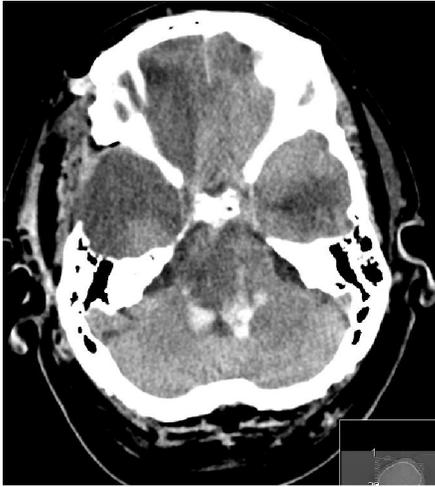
A non-enhance CT brain shows a lower cut than figure 5, at the pons level, demonstrating a hemorrhage in and around the pons with pontine expansion.
